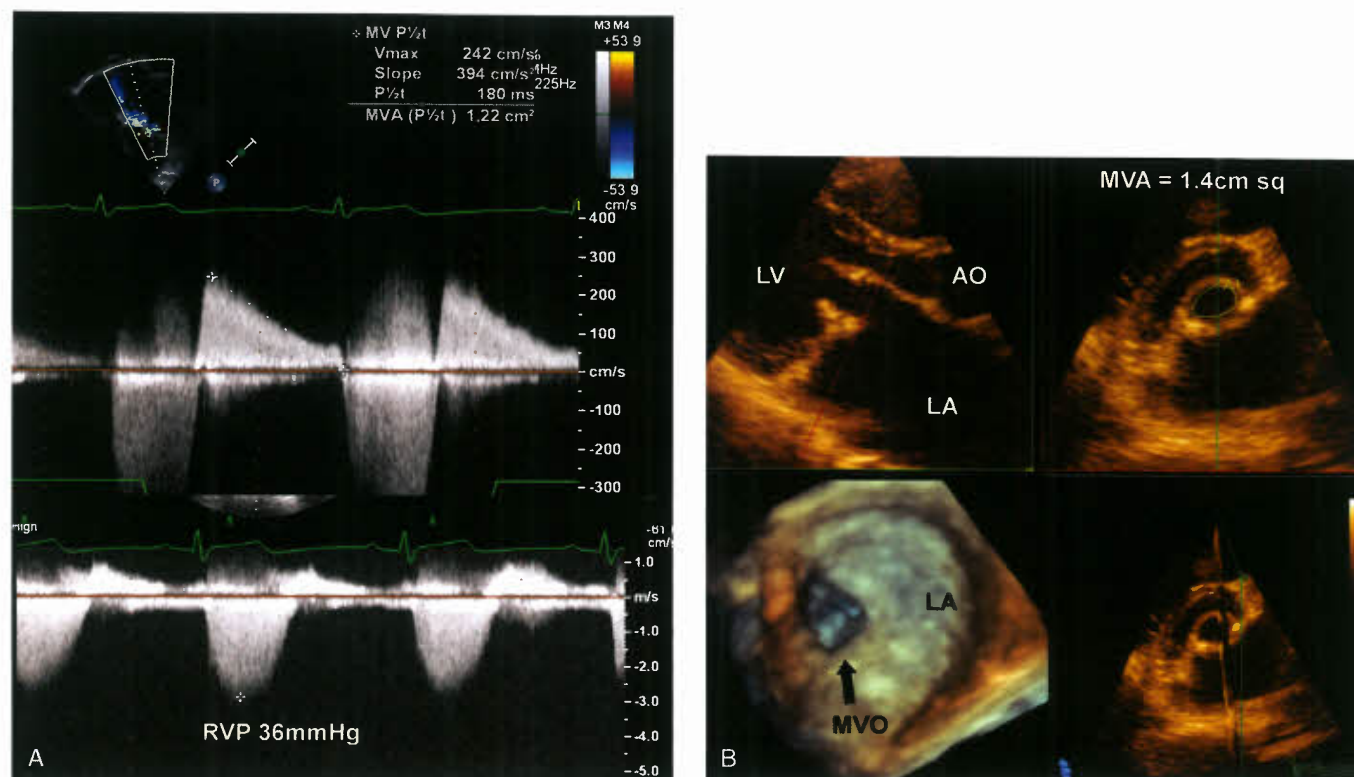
A: The upper Doppler trace is from an adolescent with a slower heart rate so that the pressure halftime could be used to calculate MV area (1.22 cm^2). The lower trace shows the right ventricular pressure from tricuspid valve regurgitation. RVP, right ventricular pressure. B: This is from the same case as Figure 45.14A and shows MV area calculation from 3-D echocardiography using the MPR mode. Note that the planimetered area of the MV is 1.4 cm^2 , which is similar to the pressure halftime calculation. The lower right hand panel shows the true MV orifice as seen from the left atrium with 3-D echocardiography. AO, aorta; LA, left atrium; LV, left ventricle; MVA, mitral valve area; MVO, mitral valve orifice.
